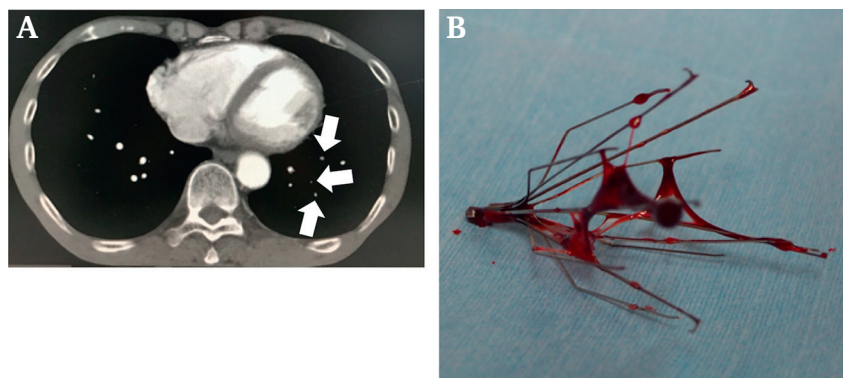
Pre- and post-operative images of pulmonary embolism. (A) Enhanced computed tomography (CT) scan in which thrombus was detected in peripheral pulmonary arteries (arrows). (B) Inferior vena cava (IVC) filter removed from the patient after treatment. Even though enhanced CT and IVC venography were performed, which ruled out major thrombus, minor thrombus was observed. This meant that the small thrombus was formed in and had travelled from the popliteal venous aneurysm.
